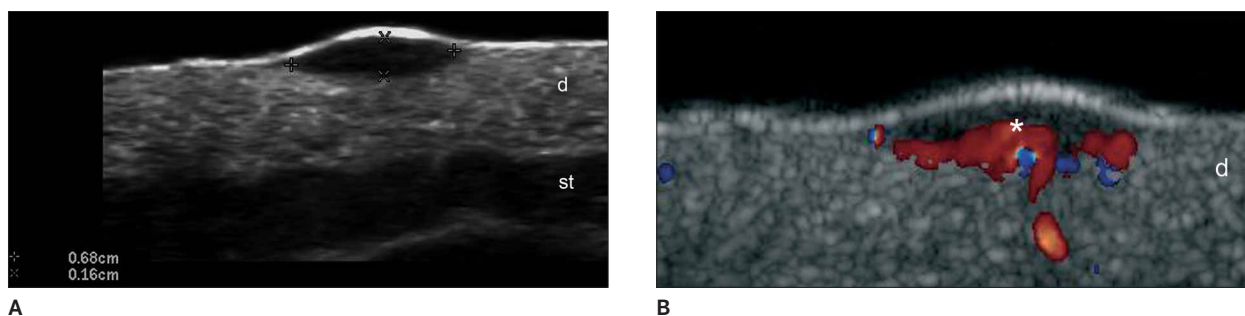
Melanoma. A, Gray scale sonography (dorsal region, transverse view) shows a 1.6-mm-deep × 6.8-mm-wide fusiform hypoechoic lesion (between markers) that involves the epidermis and dermis. There is increased thickness and echogenicity of the epidermis. Depth measurement was performed at the dermis by agreement with the pathologist. B, Color Doppler sonography shows increased blood flow within the same lesion (asterisk). Abbreviations: d indicates dermis; and st, subcutaneous tissue.
